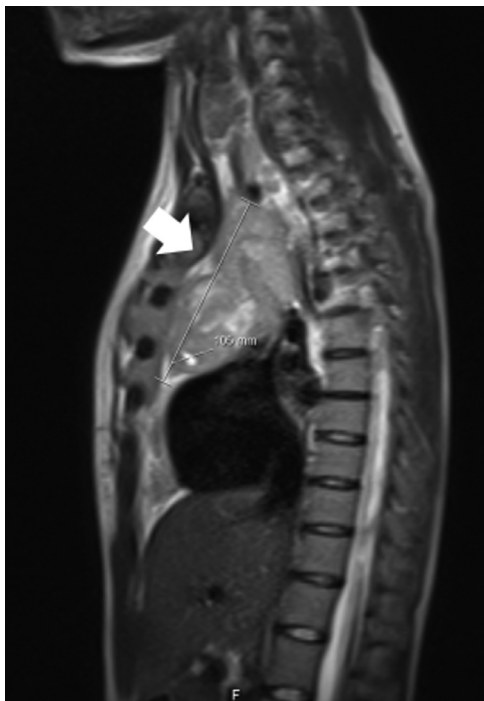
A gross mediastinal mass fully embedding the SVC (sagittal T2 MRI).
